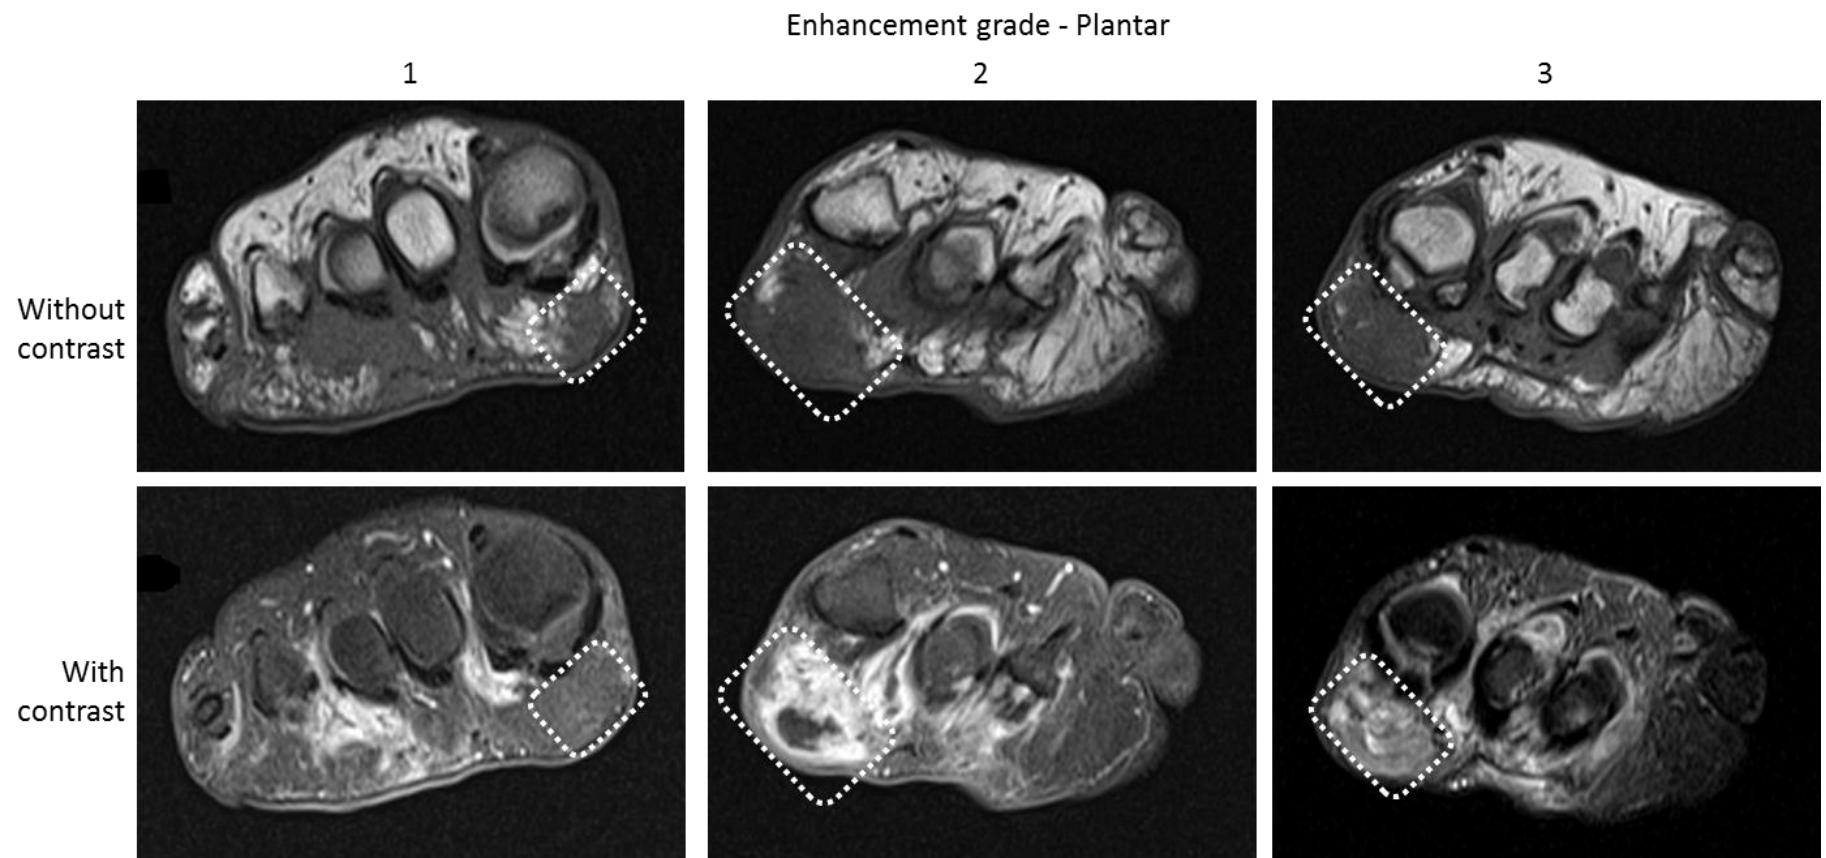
Differences in MRI-detectable FFB enhancement: plantar lesions
